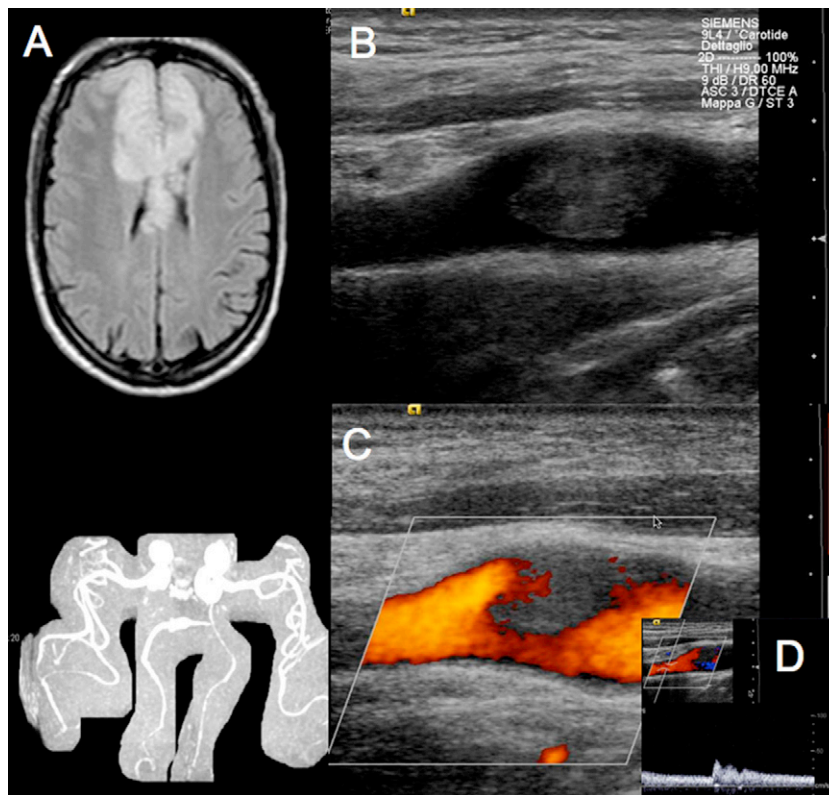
Case 2. Cerebral MR scan (A) with both anterior cerebral arteries ischemic lesions and normal middle cerebral arteries at MRA (below). Carotid ultrasonography: B-mode (B), power mode (C) of a mobile clot adherent to the superior wall of the carotid bulb. Distally, the internal carotid artery is patent, as shown by the power Doppler (B) and pulsed wave Doppler (D).
